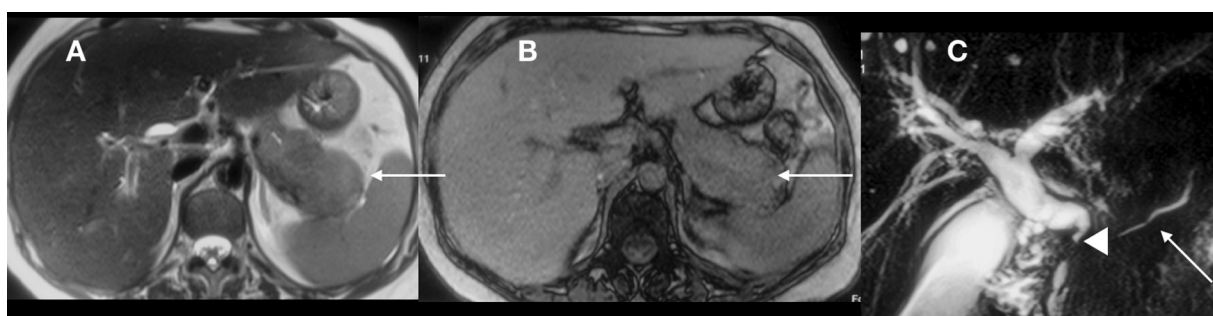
A 45-year-old male with pain abdomen and altered liver function test (LFT). Axial T2-weighted (T2W) (A) and T1W (B) images show typical fusiform enlargement of the pancreas (arrows) which shows increased T2 and decreased T1 signal. Coronal magnetic resonance cholangiopancreatography (MRCP) (C) images show narrowing at lower end of common bile duct (CBD) (arrowhead), with mildly dilated irregular main pancreatic duct (MPD). Findings are suggestive of autoimmune pancreatitis, confirmed on biopsy.
